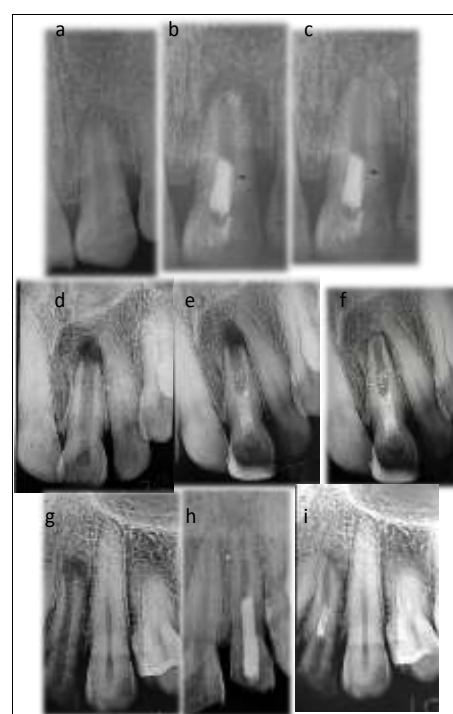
a. Preoperative periapical radiograph of tooth #11. Note immature root with open apex, b. Radiograph at 12 months follow-up, c. Radiograph at 24 months follow-up. Note the increase in Dentine thickness and root end closure, d. Preoperative periapical radiograph of tooth #21, e. Radiograph at 12 months follow-up, f. Radiograph at 24 months follow-up. Note apical close closure and root canal obliteration, g. Preoperative periapical radiograph of tooth #12, h. Radiograph at 12 months follow-up, i. Radiograph at 24 months follow-up. Note the increase in Dentine thickness and root end closure.
